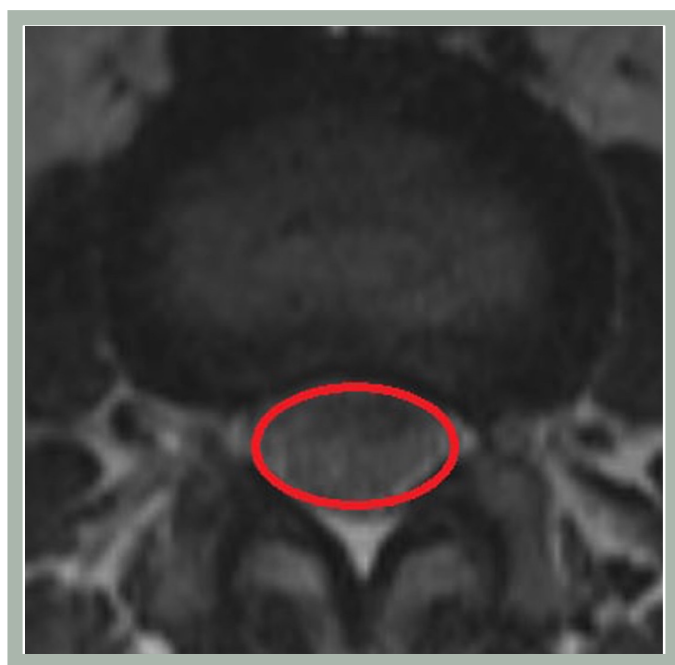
Axial T2-weighted MRI in a patient showing spinal dural sac area at the level of the disc
